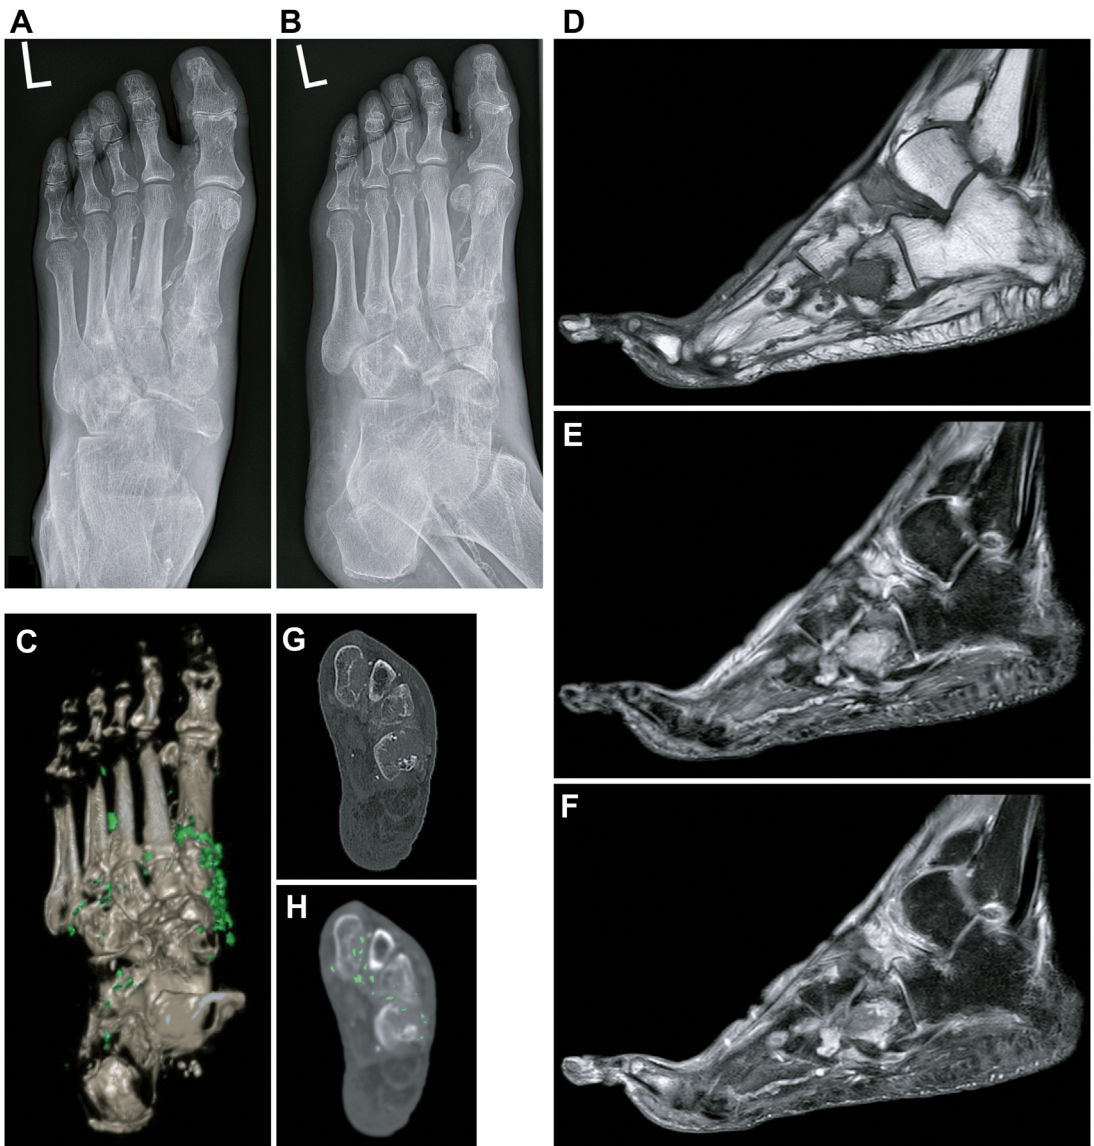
Left foot dorsoplantar (A) and $3/4$ view (B) show erosive destruction in the tarsus and MTP joints. Sagittal MR images, T1TSE (C), T2TSE fatsat (D), and T1TSE fatsat after intravenous contrast (E) show multiple sharply delineated erosions in the tarsal bones. The moderately high T2 content shows a peripheral zone of enhancement. Absence of intraosseous edema. DECT, 3D-formatted (F), axial subtracted images in bone (G) and soft tissue (H) setting. Color-coded green MSU deposits in the erosions. 3D, 3-dimensional.
